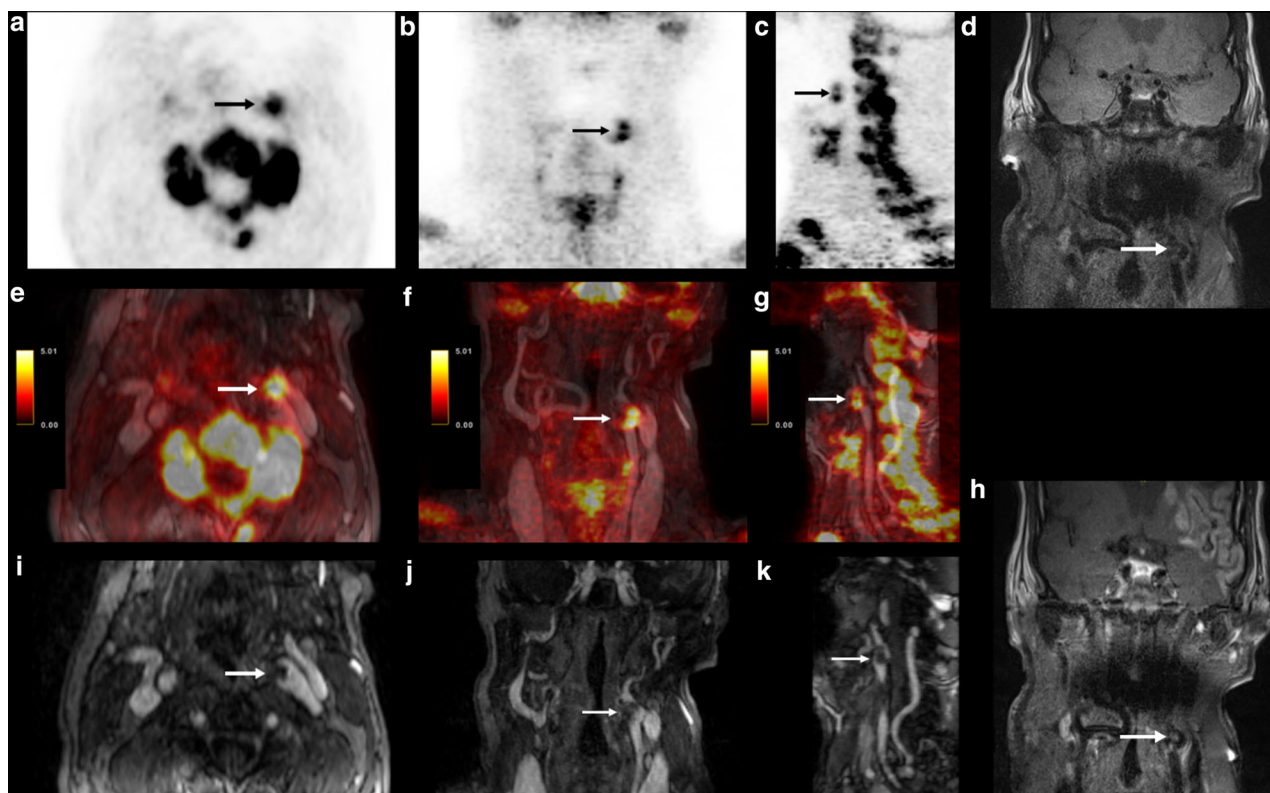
^{18}F -sodium fluoride positron-emission tomography/magnetic resonance (^{18}F -NaF PET/MRI) PET/MRI from a 59-year-old patient (No. 11) who experienced right hemiparesis and aphasia related to left middle cerebral artery territory infarct. Axial, coronal, and sagittal views of PET (A–C) showing ^{18}F -NaF uptake into the left carotid plaque (black arrow). Axial, coronal, and sagittal views of merged PET/MRI (E–G) images showing ^{18}F -NaF uptake overlaid on the T1-w images (black arrow); Axial, coronal, and sagittal views of contrast-enhanced angiography (I–K) showing an eccentric plaque of the left carotid artery causing a luminal stenosis; Coronal T1-weighted MR images pre- and post-gadolinium showing a macrocalcification and a focal enhancement of the plaque (D, H).
